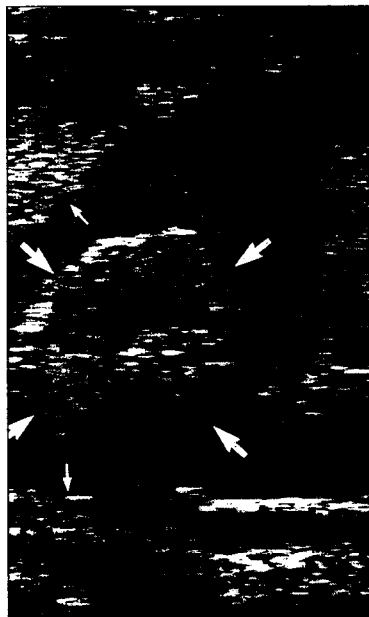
Transrectal ultrasonogram of the bladder of the same stallion 3.5 years after initial admission. Soft-tissue masses (large arrows) surrounded by urine and sediment can be seen protruding from the bladder wall (small arrows) into the bladder lumen. (5 MHz, linear)
